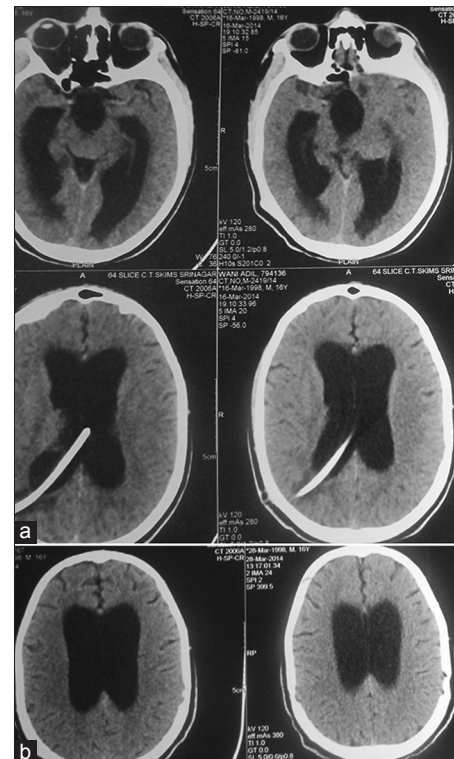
Computed tomography scan axial sections show malfunctioning shunt (a), postendoscopic third ventriculostomy size of the ventricles has not changed though (b) (though patient improved clinically)
